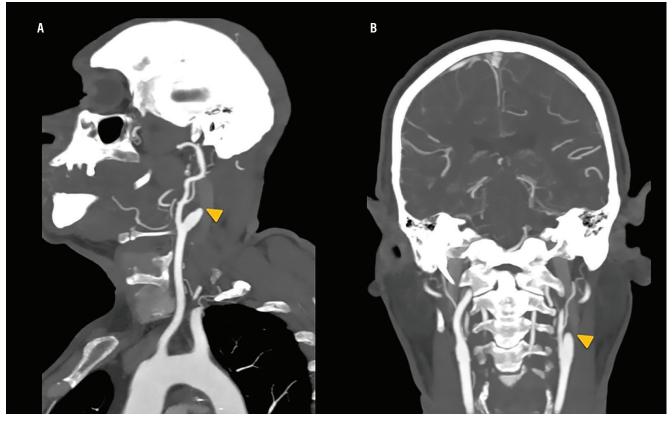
Sagittal (A) and coronal (B) CT angiography show a complete occlusion of the proximal cervical segment of the left internal carotid artery (arrowheads).
